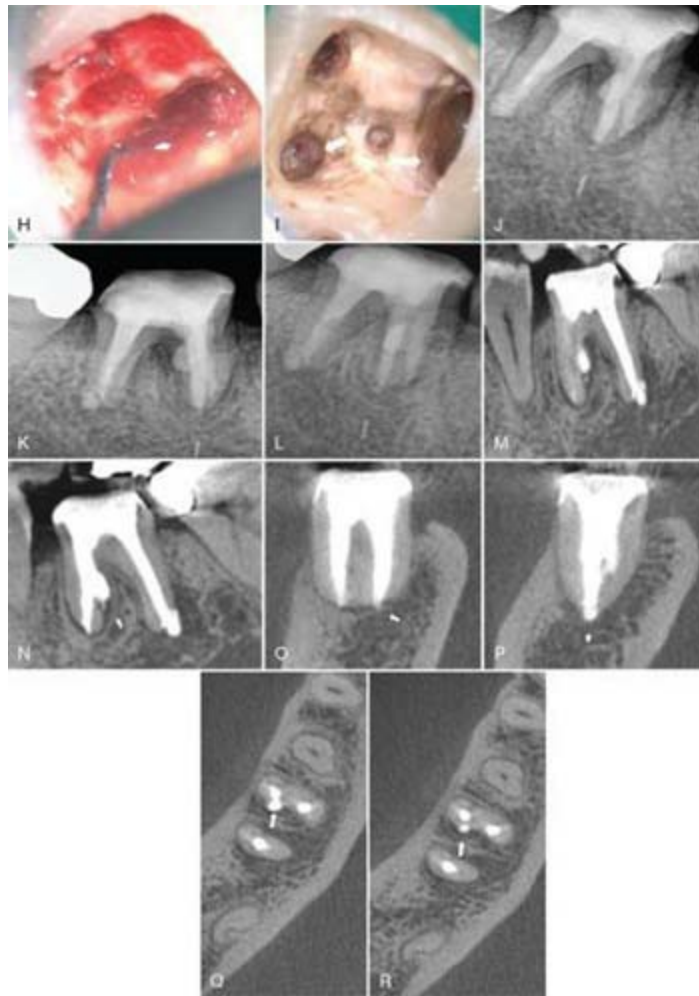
A, Preoperative radiograph of the mandibular right first molar showing extruded root filling materials into periapical tissues (*red arrows*). B1 and B2, Cone-beam computed tomography (CBCT) images in axial view showing the perforation site from the mesiobuccal canal into the furcation (*red arrow*). C, CBCT image in sagittal view showing extruded root fillings from the distal root (*red arrow*) and the perforation (*white arrow*). D1 and D2, CBCT images in coronal view showing the mesial root without extruded root fillings (*red arrow*) (D1) and the distal root with extruded root fillings (*red arrow*) (D2). E, Magnification of the MB canal with perforation (*red arrow*). F, Intraoperative radiograph showing removal of the intracanal root fillings. G, Magnification of the MB canal showing removal of the extruded root fillings from the perforation with an XP-Endo Shaper. H, Magnification of the distal canal showing removal of the extruded root fillings from the distal root end with an XP-Endo Shaper. I, Magnification of the root canals after the removal of extruded root fillings (*white arrows*). J, Postoperative radiograph showing all the root canals including the perforation were successfully filled with mineral trioxide aggregate (MTA). K, Three-month postoperative radiograph showing reduced periapical lesions. L, Ten-month postoperative
